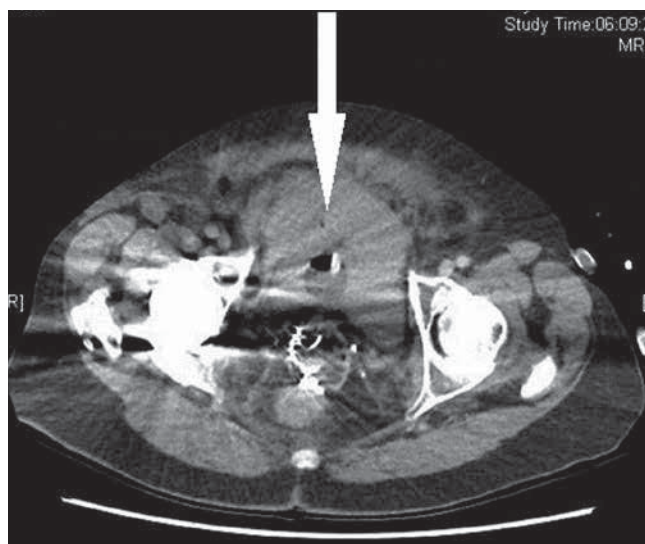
CT pelvis. Arrow indicates retroperic hematoma.
